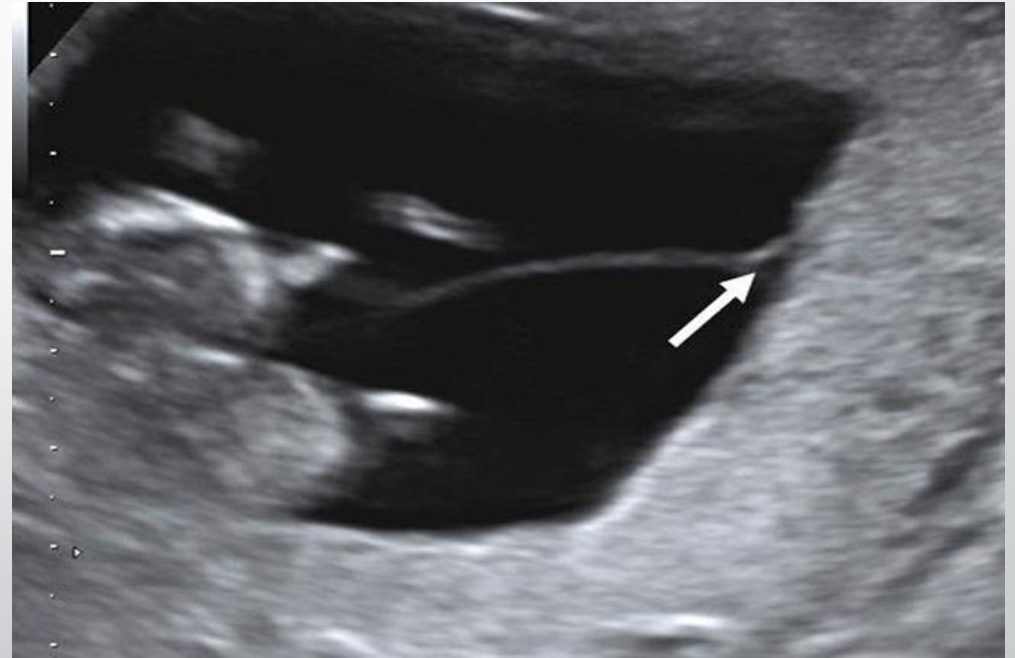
Ultrasound appearance of monochorionic (a) and dichorionic (b) twin pregnancies at 12 weeks' gestation. Note that in both types there appears to be a single placental mass but in the dichorionic type there is an extension of placental tissue into the base of the inter-twin membrane forming the lambda sign.
